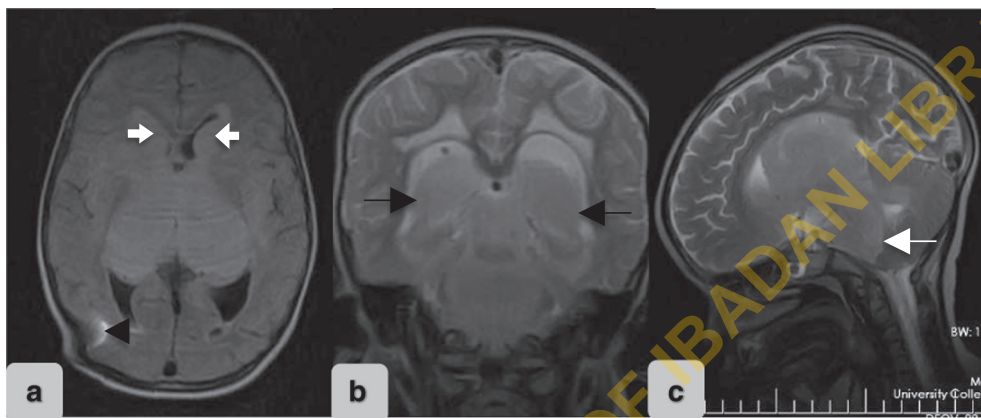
(a–c): Non-contrast enhanced brain MRI (six months post-endoscopic transventricular tumour biopsy).
